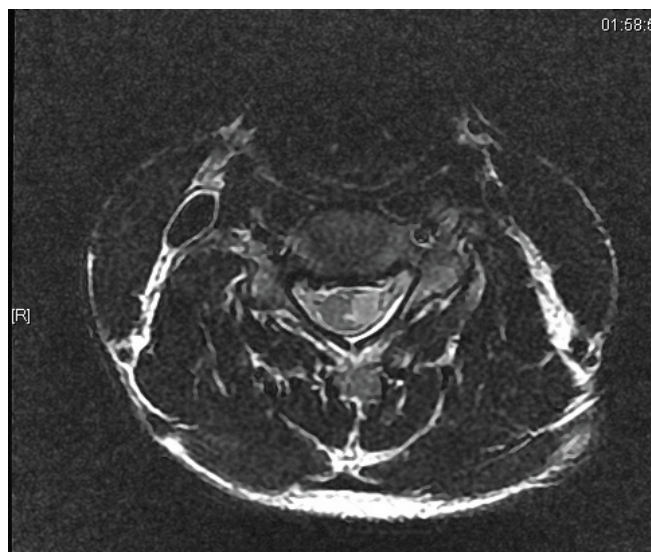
Axial T2-weighted MRI at C4 and C5 levels demonstrates the extent of spinal cord hyperintensity limited to the left hemicord in keeping with the clinical features of Brown-Sequard syndrome.
